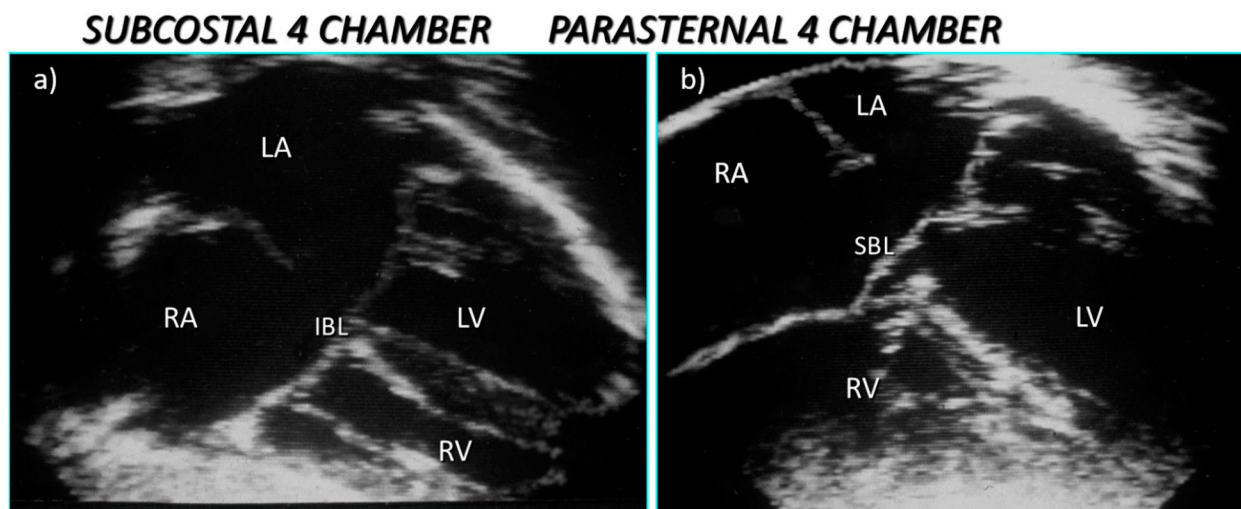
Echocardiography sections from a partial atrioventricular septal defect showing (a) the primum defect and inferior bridging leaflet in the subcostal section and (b) the anterior and bridging leaflet in the apical section with an obvious recess beneath the superior bridging leaflet.
